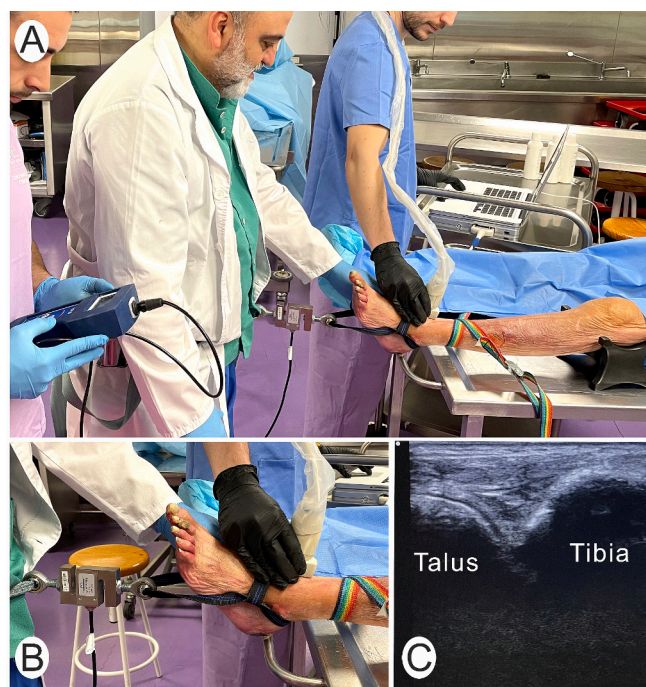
A) Experimental set-up. B) Tibiotarsal traction strap, digital force gauge and transducer position at the anterior part of the ankle joint. C) Ultrasound image of tibia and talus at rest as baseline.
